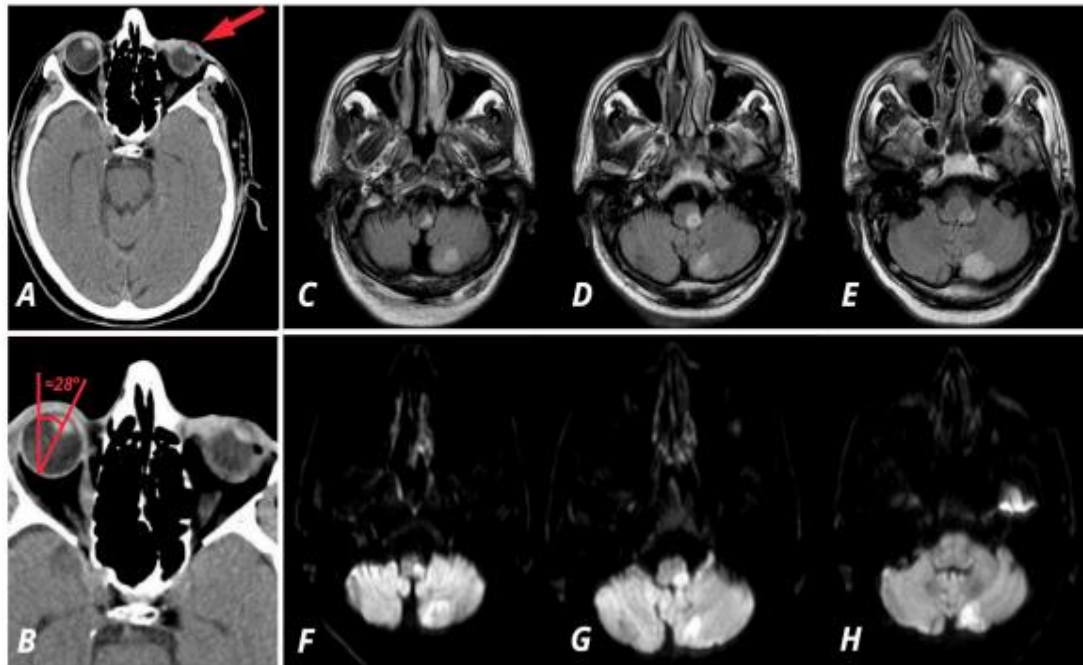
Brain CT and MRI. A: Admission CT shows leftward ocular deviation (arrow); B: Deviation angle; C-E: MRI FLAIR images; F-H: MRI DWI reveals ischemic stroke in the left retro-olivary medulla, extending to the upper medulla and ipsilateral cerebellar hemisphere, affecting the inferior semilunar lobe and the nucleus prepositus hypoglossi, within the left posterior-inferior cerebellar artery.
